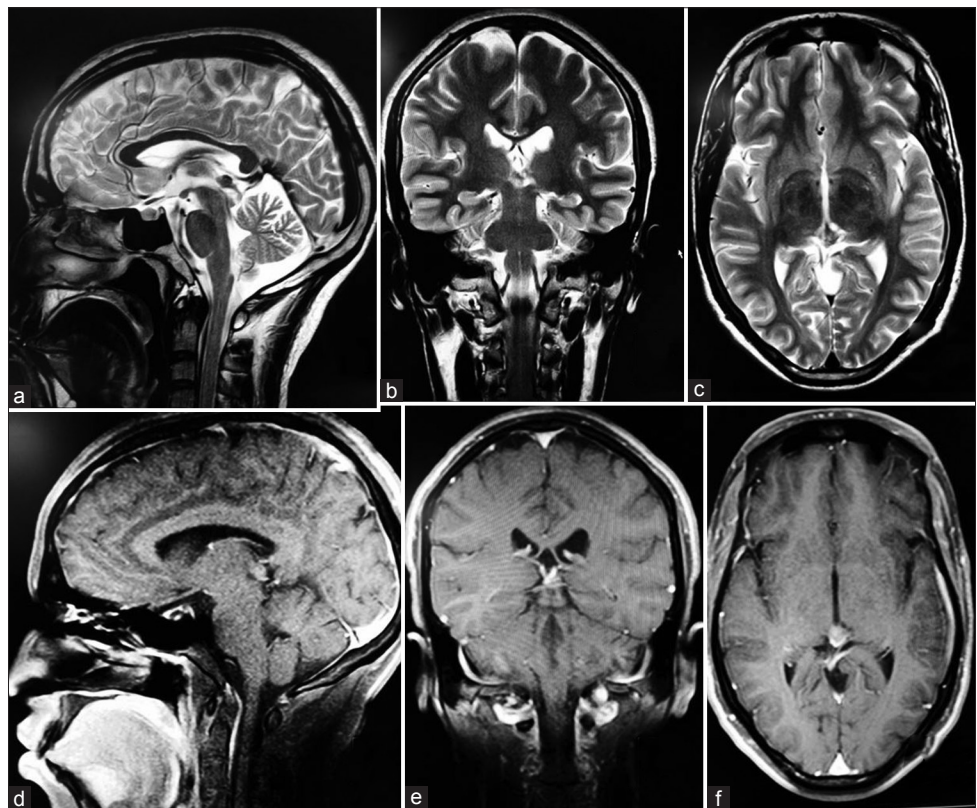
Follow-up MRI study of the patient. The top panel depicts the plain images: (a) T2W sagittal, (b) T2W coronal, and (c) T2W axial. The lesion demonstrates more than 90% resolution. (d-f) Postcontrast images, with a small tumor seen in the axial section
